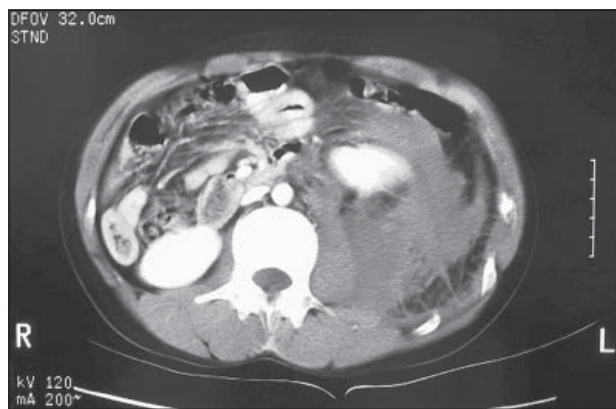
Contrast axial computed tomography scan of the abdomen showing a large left retroperitoneal haematoma surrounding the left kidney.
